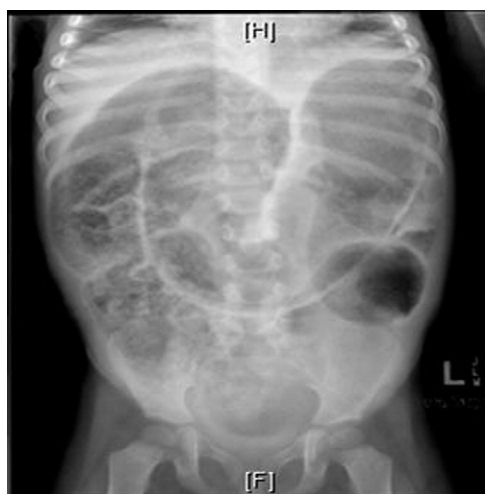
Abdominal radiograph of a 3 year-old child presenting with abdominal distention, fever, and vomiting 1 year after a pull through procedure. Enterocolitis was treated with irrigations and metronidazole. The patient subsequently underwent a redo pull through for persistent transition zone bowel.
